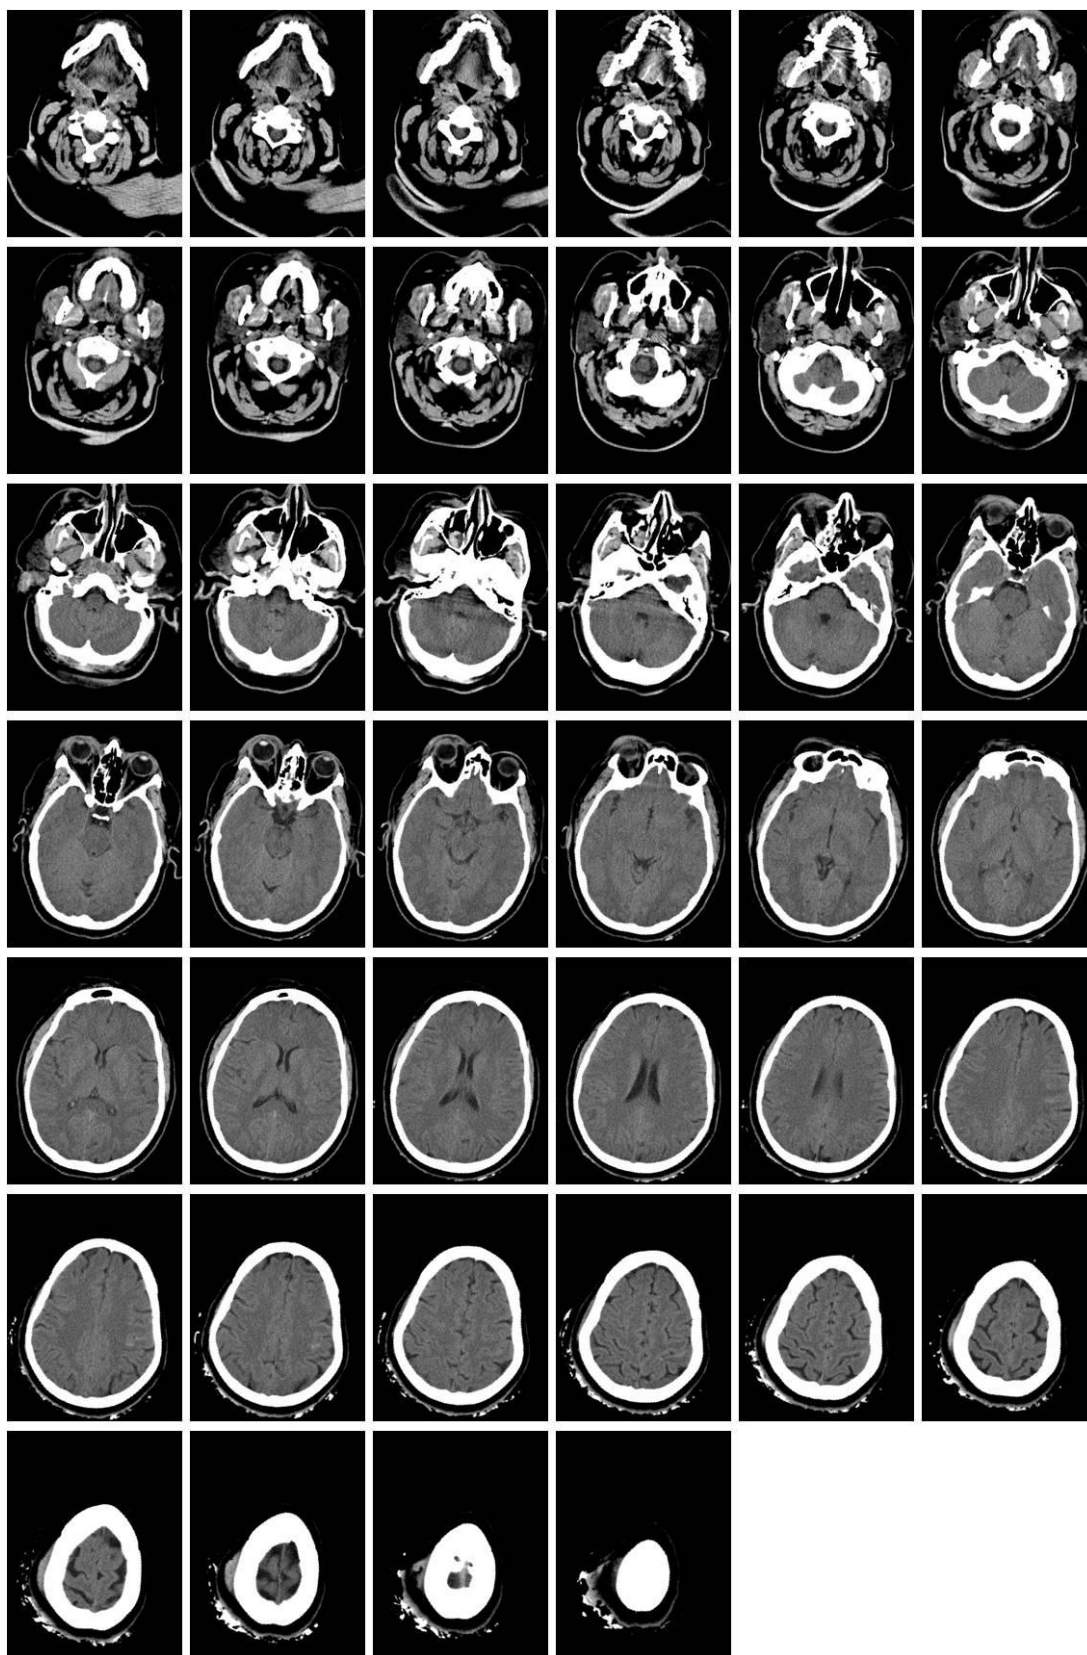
Raw CT slices (40 slices) from one patient's head CT scan.
